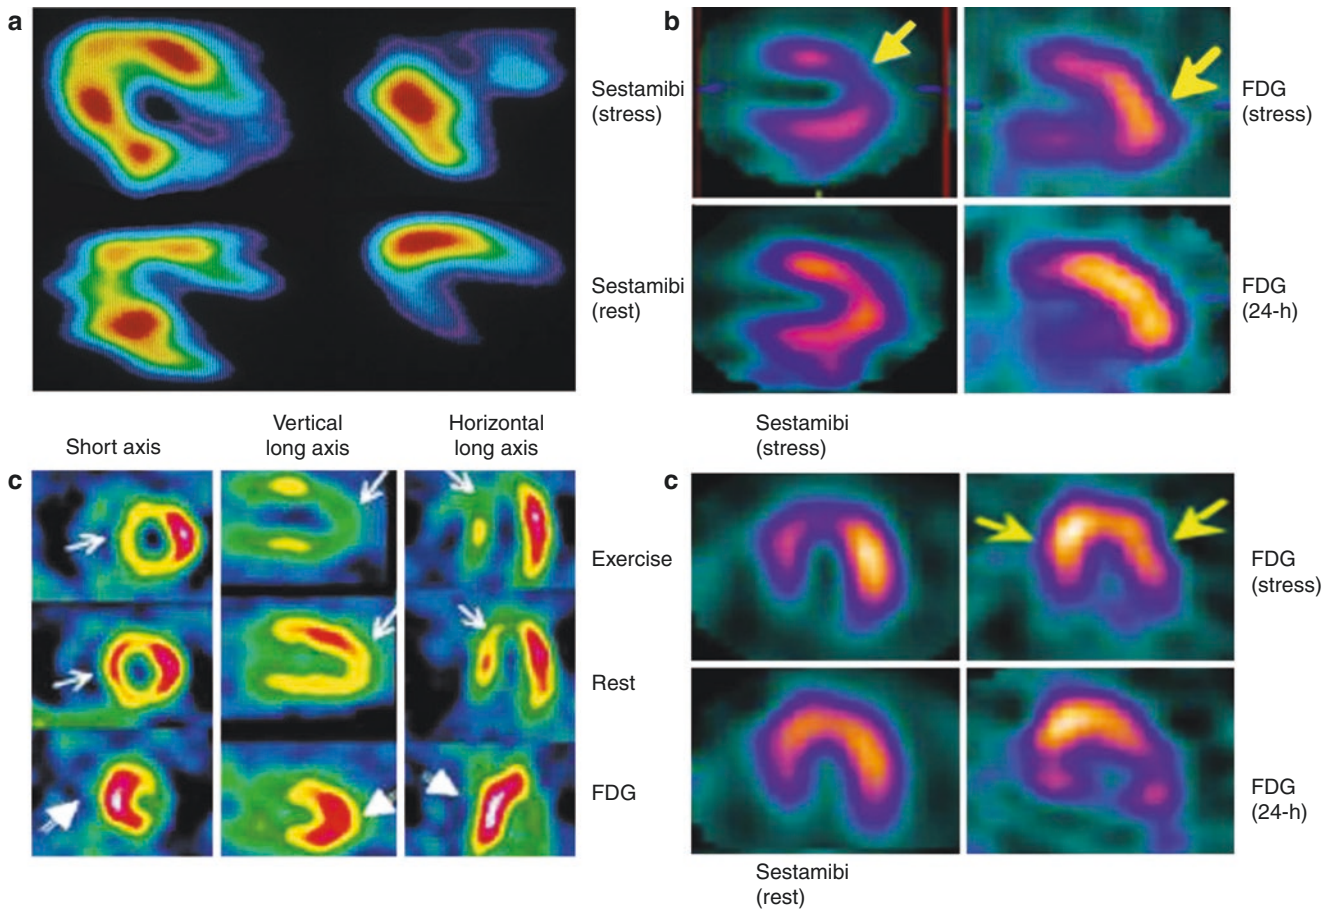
Metabolic alterations in postischemic myocardium in patients with angina. Physical exercise is probably the most common precipitating factor responsible for myocardial ischemia in patients with coronary artery disease manifested as angina and, most importantly, left ventricular dysfunction (mismatch of supply and demand). Although the recovery of such stress-induced left ventricular dysfunction is thought to occur within minutes after the termination of exercise, persistent contractile dysfunction has been observed in some patients up to 90 minutes after the termination of exercise, which has been attributed to stunned myocardium. (a) Transaxial rubidium-82 (⁸²Rb) PET images reflecting myocardial blood flow at rest, during exercise, and after exercise are shown along with FDG images after exercise. At rest (*top left*), the distribution of myocardial blood flow is homogeneous in all myocardial regions. During exercise (*top right*), there are extensive blood flow abnormalities in the apical and anteroseptal regions that improve on the postexercise images (*bottom left*) and are comparable to the ⁸²Rb rest image (*top left*). FDG was injected 8 minutes after the termination of exercise. The FDG image recorded 60 minutes after tracer injection (*bottom right*) shows metabolic alterations in the previously ischemic regions. (b) An example of perfusion/metabolism mismatch. Shown are simultaneous myocardial perfusion and metabolism imaging after dual intravenous injection of ^{99m}Tc-sestamibi and FDG at peak exercise. Dual isotope simultaneous acquisition was carried out 40–60 minutes after the exercise study was completed. Rest ^{99m}Tc-sestamibi imaging was carried out separately. In this patient with angina
